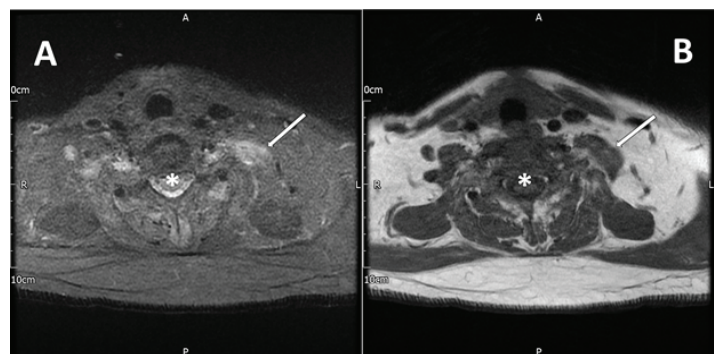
MMRI axial STIR (A) and axial T1 (B) weighted images of the brachial plexus at the level of C6/7 intervertebral disc showing diffuse asymmetric high signal oedema involving the left brachial plexus with ill-defined thickening of the nerves at this level (white arrow). The cervical spinal canal is marked with the asterisk. (MRI – magnetic resonance imaging; STIR – short tau inversion recovery).short tau inversion recovery).
